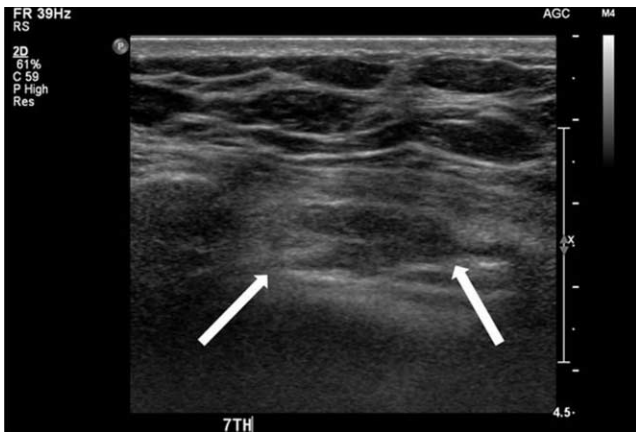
Ultrasonography shows an oval shaped, low echoic mass measuring about 1.8×0.6 cm in the left intercostal muscle. On color Doppler study, increased blood flow is not seen within the mass (not shown).
